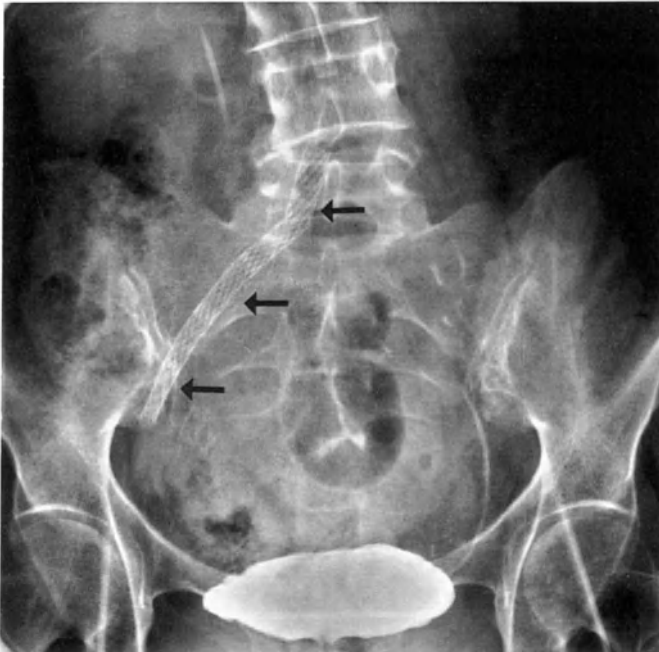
Plain radiograph of multiple overlapping stents (arrow) in the right common and external iliac artery. Note the radiologic clarity (visibility) which aids in proper placement of the stents.
